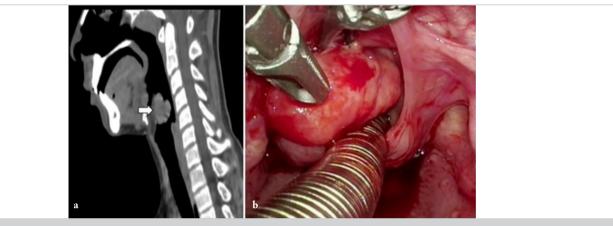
Original epiglottic tumor. a) Sagittal computed tomography with contrast that shows a polypoid solid lesion of 20.6x21.1x23.7 mm (white arrow) with an hyperdense periphery and a less dense center without epiglottic cartilage or pre-epiglottic fat involvement and without pathological adenopathy; b) Intraoperative endoscopic view of the epiglottis attached mass obstructing the supraglottic airway being resected with the grasping tip of the ultrasonic scalpel
